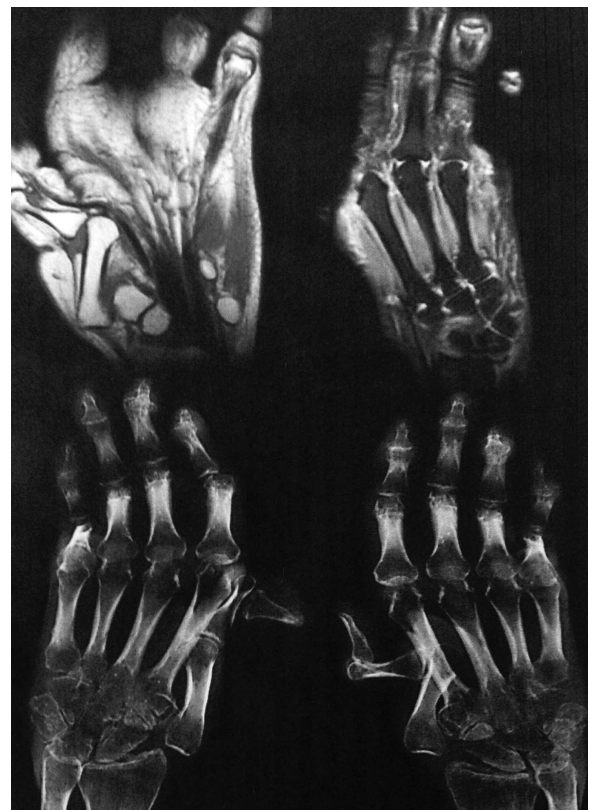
Coronal T1- and T2-weighted, fat-suppressed magnetic resonance images of the hands reveals mild synovitis and tenosynovitis without any erosion. Plain radiograph of the hands shows joint luxations, but no evidence of bone erosion.
